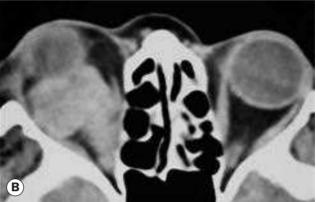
Metastatic renal carcinoma. (A) Proptosis; (B) axial CT showing a non-encapsulated retrobulbar mass (*Courtesy of A Pearson – fig. B*)
